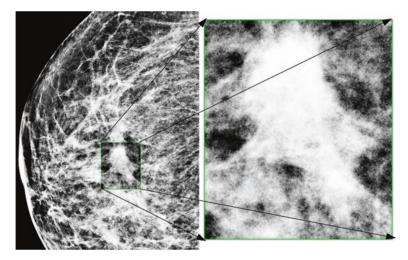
Part of the original X-ray mammogram image with the part of the image having the abnormality enlarged
